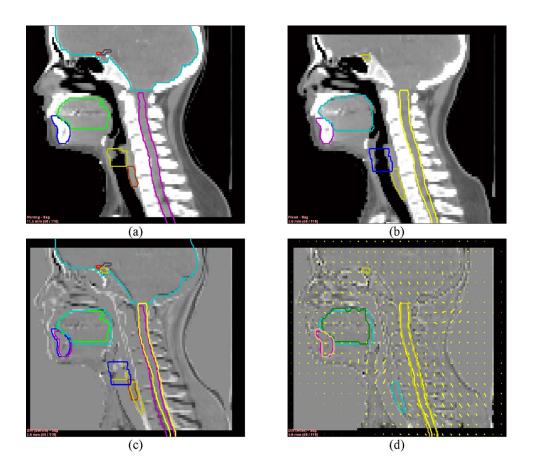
Demonstration of deformable image registration and structure contour remapping on the H/N cancer patient. (a) The initial CT scan with the initial structure contours. (b) The second CT scan with the secondary structure contours. (c) The different images before deformable image registration with both sets of structure contours. (d) The different images after image registration overlaid with deformation vectors, with the remapped initial structure contours and the secondary structure contours.
